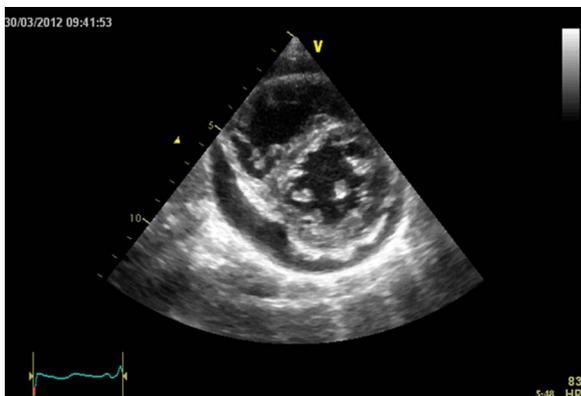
Pericardial effusion and pericardial metastasis on transthoracic echocardiography (parasternal short axis view, arrowed).
